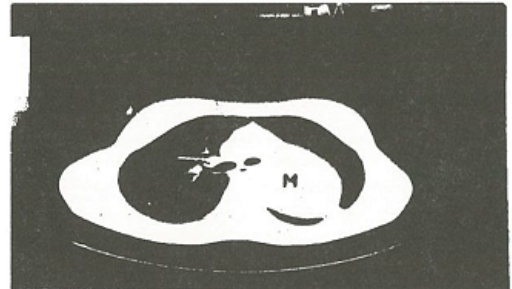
Solid extrapulmoner upper-left mediastinal mass (M) is seen at the chest CT.
